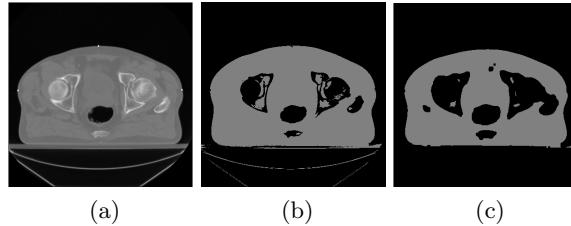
(a): One slice of the image volume produced in a CT scan of a male pelvis. (b): A binary mask created after applying a threshold to separate soft tissue. (c): The result of eroding the binary mask in (b) using a 3D structuring element of size $5 \times 5 \times 3$.
